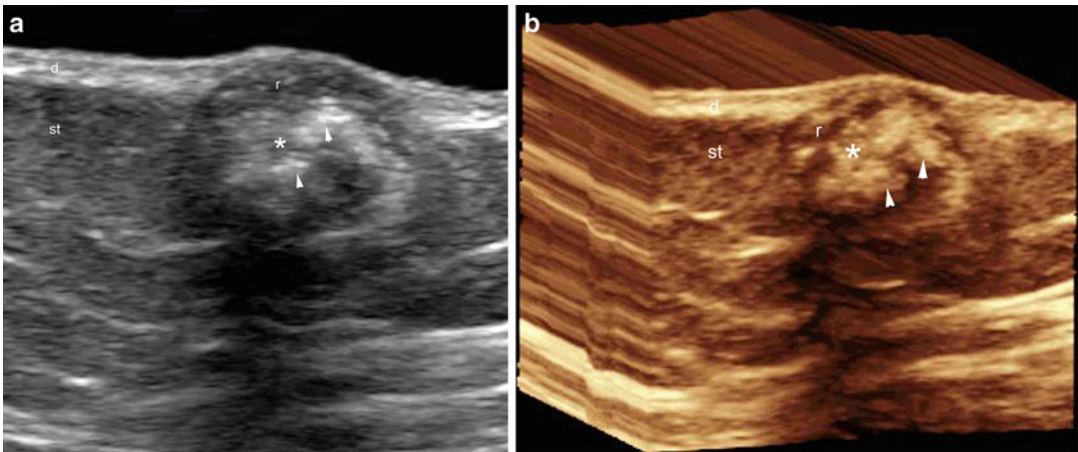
Pilomatrixoma (longitudinal views, anterior aspect of the left leg). (a) Grayscale and (b) 3D reconstruction ultrasounds show dermal and subcutaneous, target-type structure with an hypoechoic rim (r) and hyperechoic
